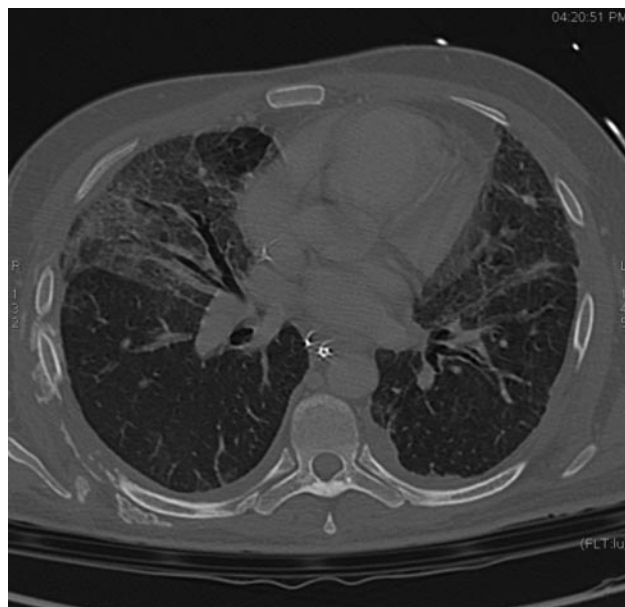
Thin section chest computed tomogram performed before discharge, demonstrating partial resolution of ARDS condition with fibrosis evolution.
